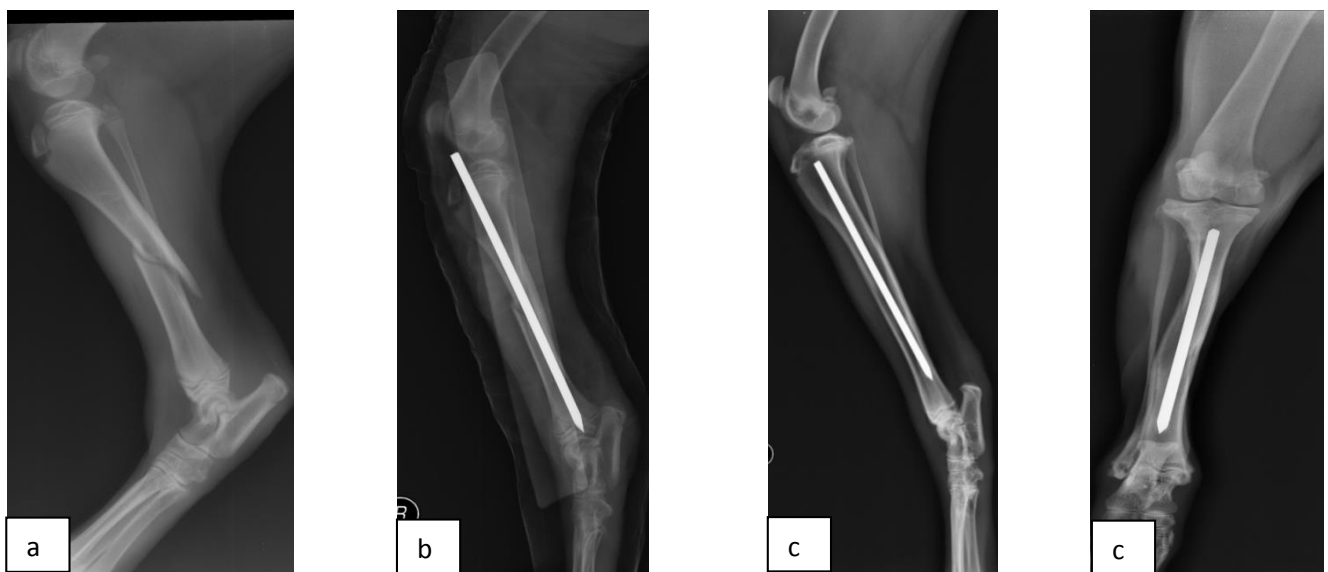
(a) Pre operative and (b) immediate post operative radiographs showing transverse fracture stabilized with intramedullary pin.
